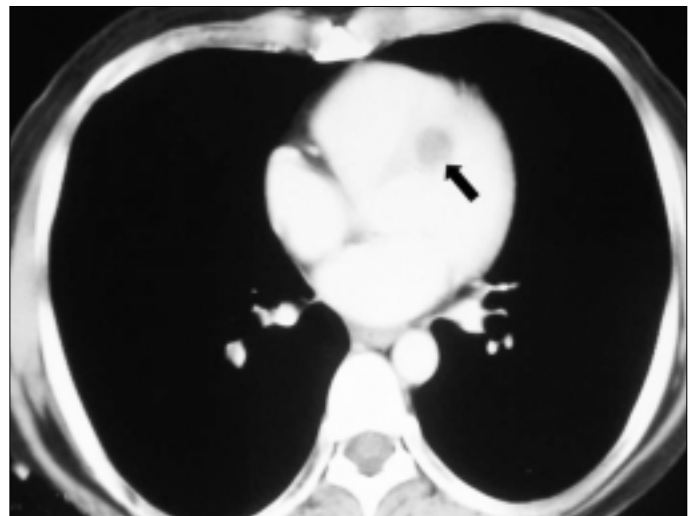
Thoracic computed tomography demonstrating a cystic lesion located in interventricular septum (Arrowhead)
